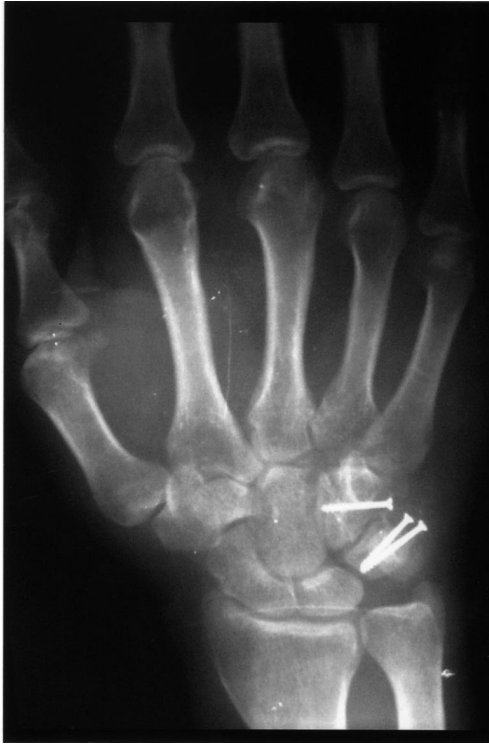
P-A X-ray of the right wrist 4 years after the operation.
